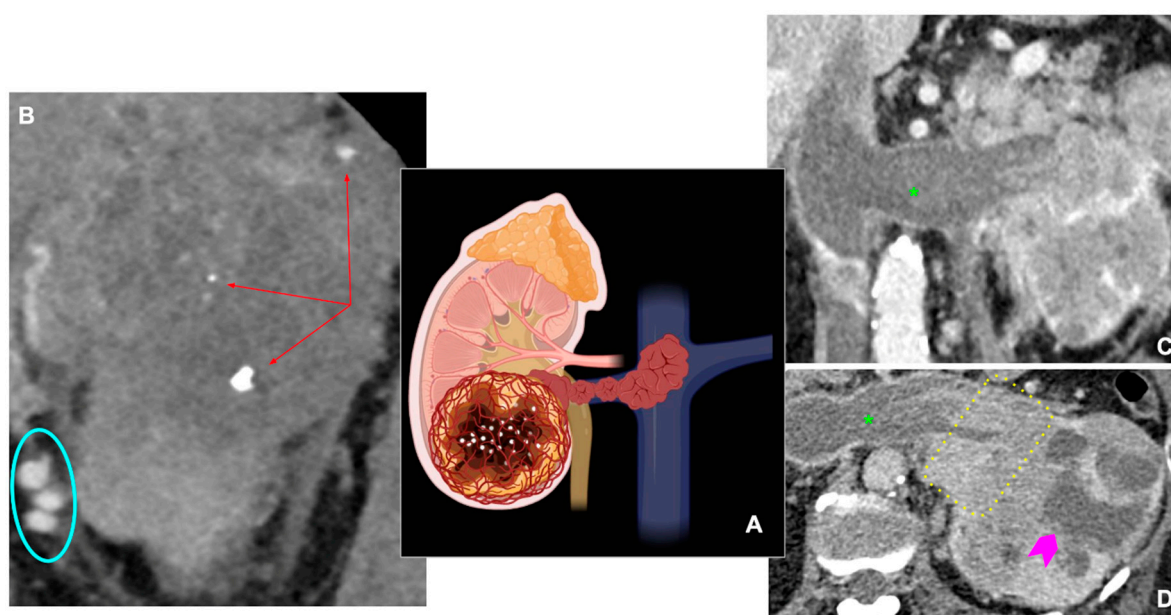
A. Central figure representing different morphological CT features associated with aggressive renal tumors. *Image created with BioRender.* B. Prominent peritumoral vessels (blue oval) and calcifications (red arrows) in a large heterogeneous renal mass. C, D. Ill-defined, infiltrating renal mass showing necrotic areas (pink arrowhead), venous tumoral thrombosis (*) and renal sinus infiltration (yellow rectangle).
